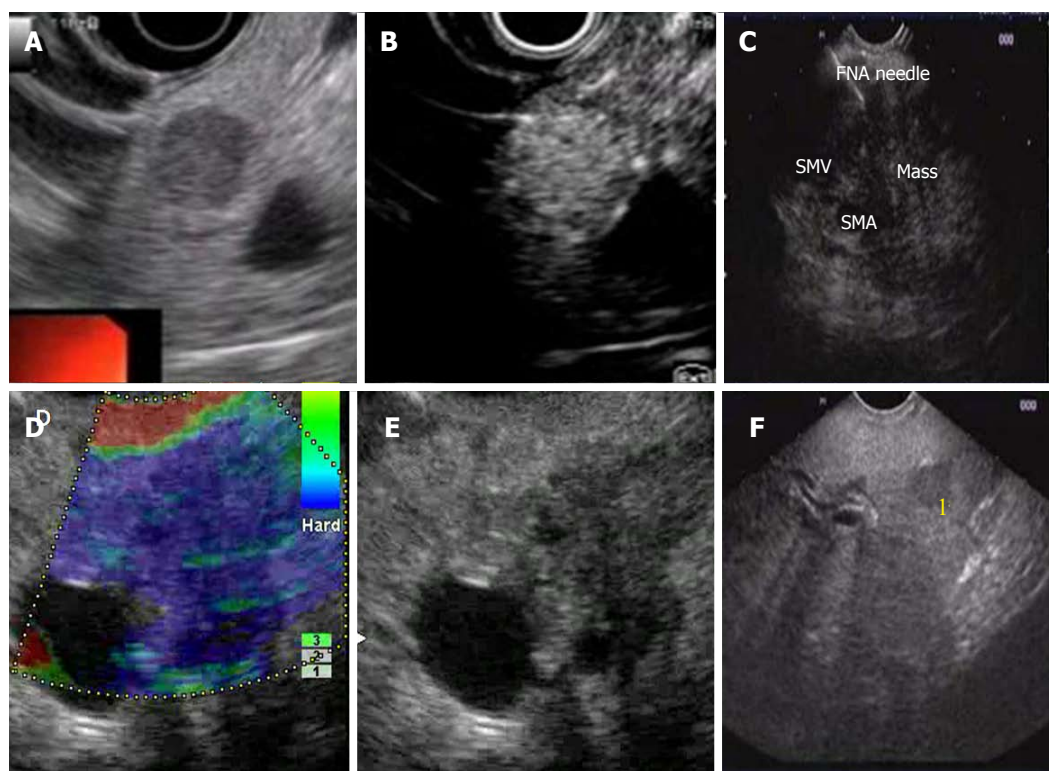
Contrast enhanced endoscopic ultrasound and endoscopic ultrasound elastography. A and B: Neuroendocrine tumor in the head of pancreas (HOP) before (A) and after (B) contrast administration; C: Fine needle aspiration (FNA) of mass in the HOP; D and E: Carcinoma HOP, EUS elastographic (D) appearance and B mode EUS appearance (E); F: Carcinoma HOP with metastasis (1) in the left lobe of liver..
